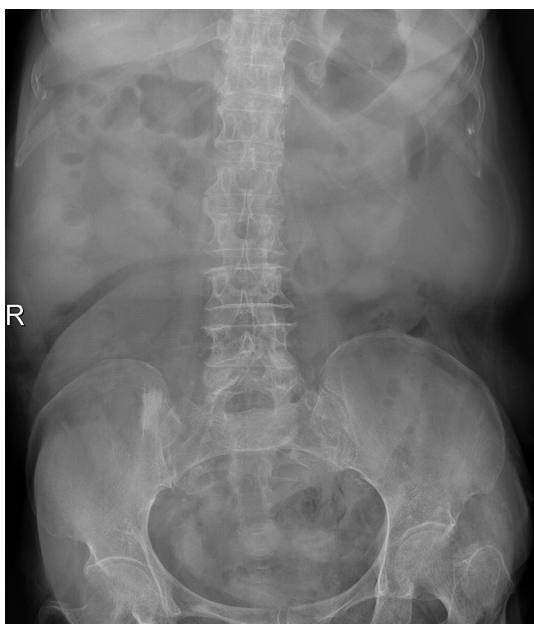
Plain abdominal X-ray shows normal bowel gas pattern.
